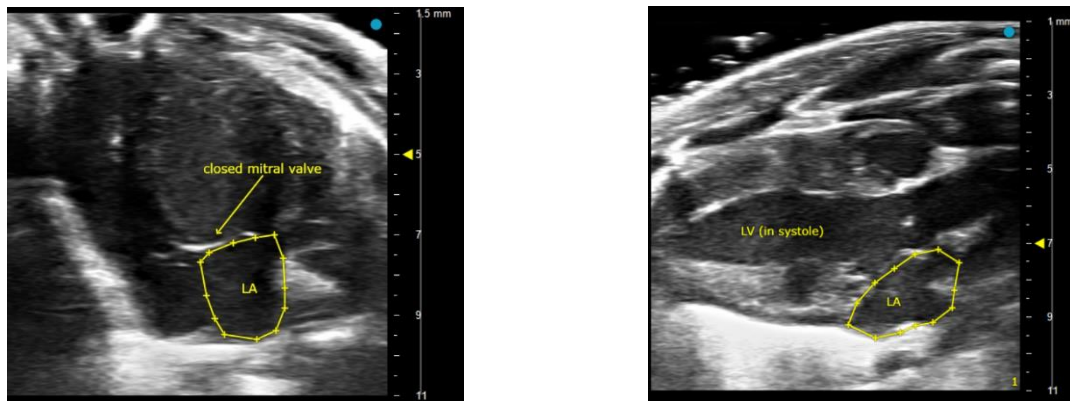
Left atrium area outline in apical 4 chamber view (left) and PSLAX view (right).
